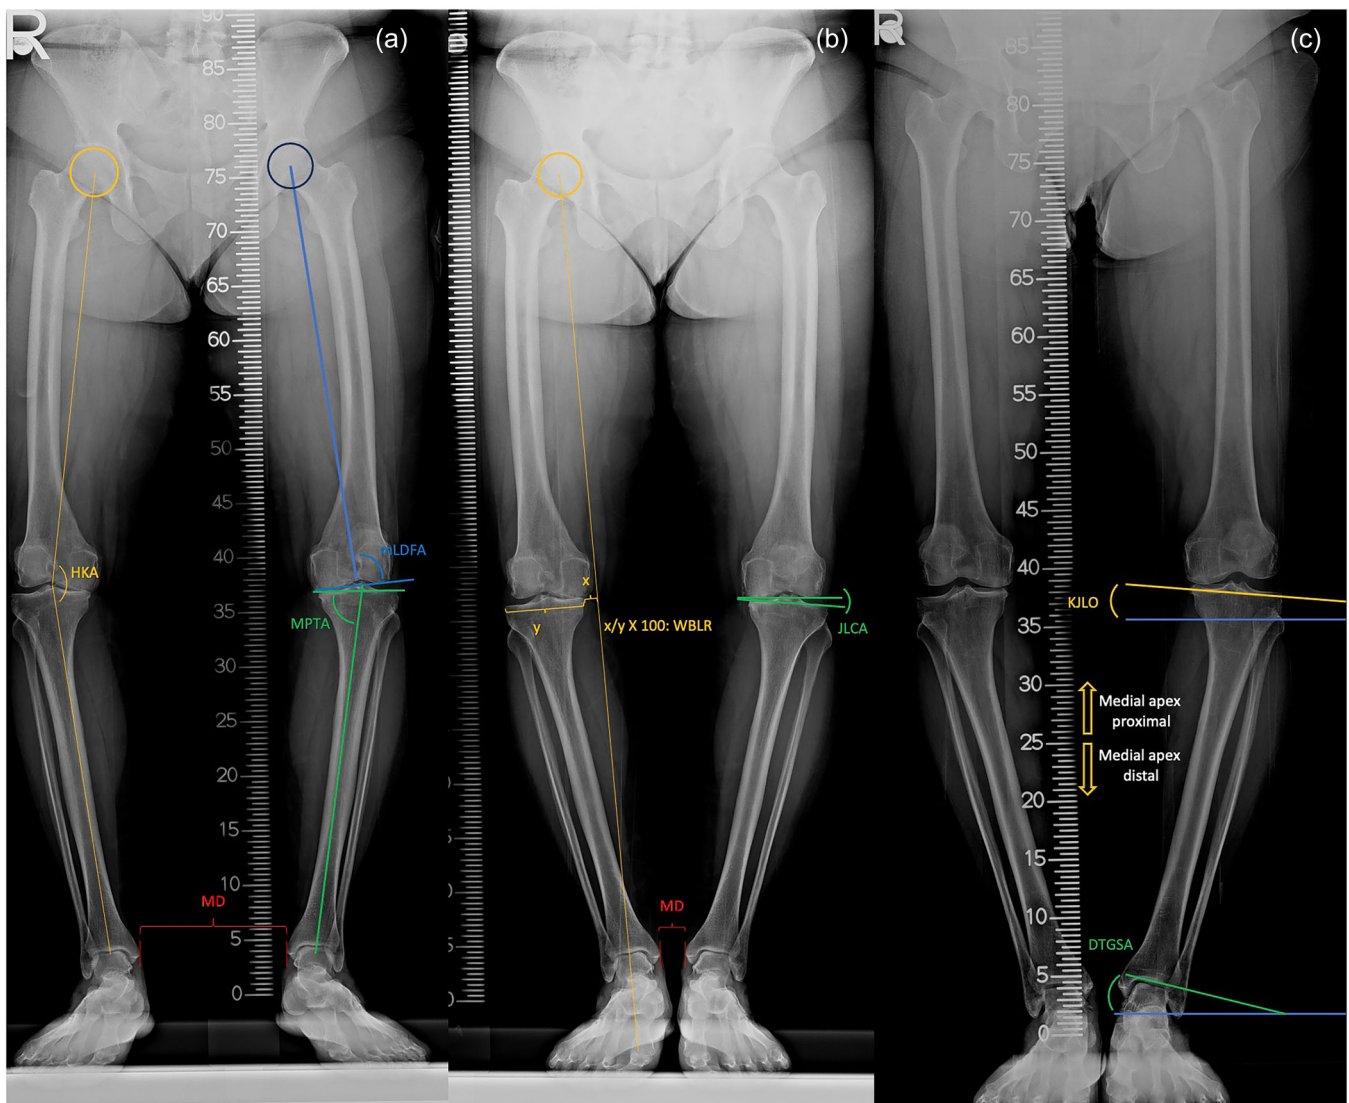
Measurements in long-LSRs. (a) The measurement of malleolar distance refers to the distance between lines drawn perpendicular to the ground and tangent to both malleoli. (b) WBLR was recorded as positive (+%) when the WBL passed through the joint and as negative (-%) when it passed medial to the joint. (c) KJLO refers to the angle formed between the line tangent to the proximal tibial articular surface (yellow line) and the ground (blue line), while DTGSA refers to the angle formed between the line tangent to the distal tibial articular surface (green line) and the ground (blue line). DTGSA, distal tibial ground surface angle; HKA, hip knee ankle; JLCA, joint line convergence angle; KJLO, knee joint line obliquity; LSRs, leg standing radiographs; MD, malleolar distance; mL DFA, mechanical lateral distal femoral angle; MPTA, medial proximal tibial angle; WBL, weight-bearing line; WBLR, weight-bearing line ratio.
